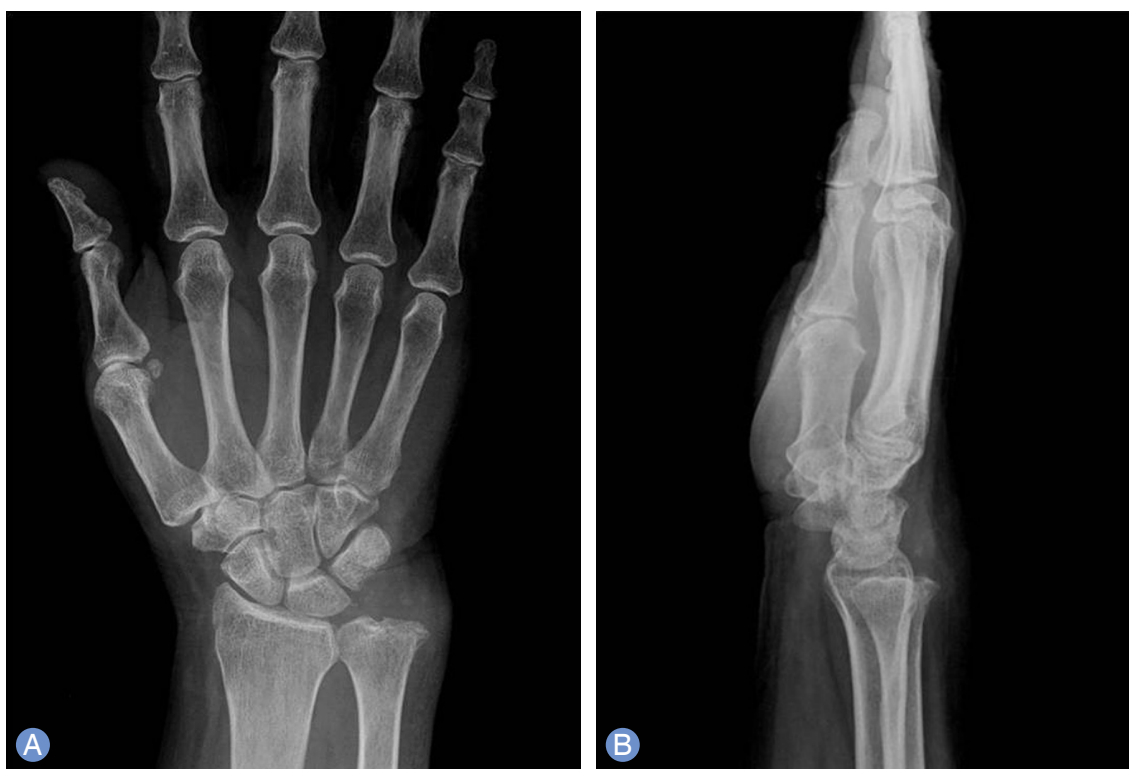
Anteroposterior (A) and lateral (B) radiographs demonstrating no evidence of recurrent disease at 18 months post-operative follow-up.
